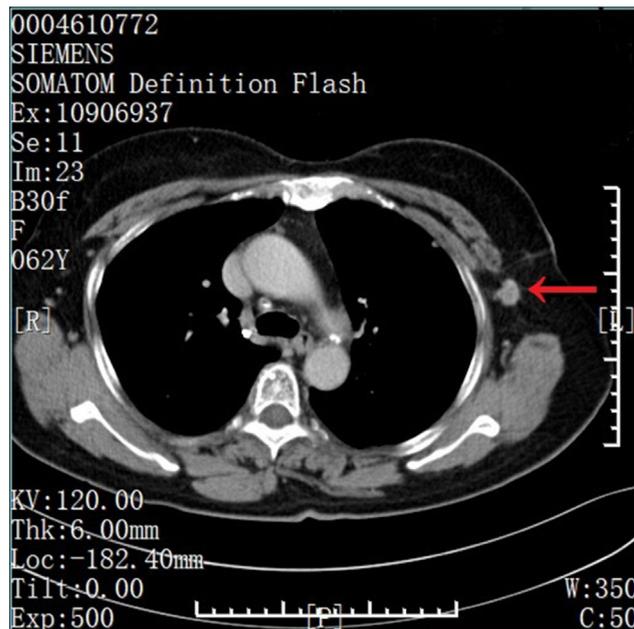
CT enhancement scan. The lymph node is shown as the mainly intensification of edge (arrow).
